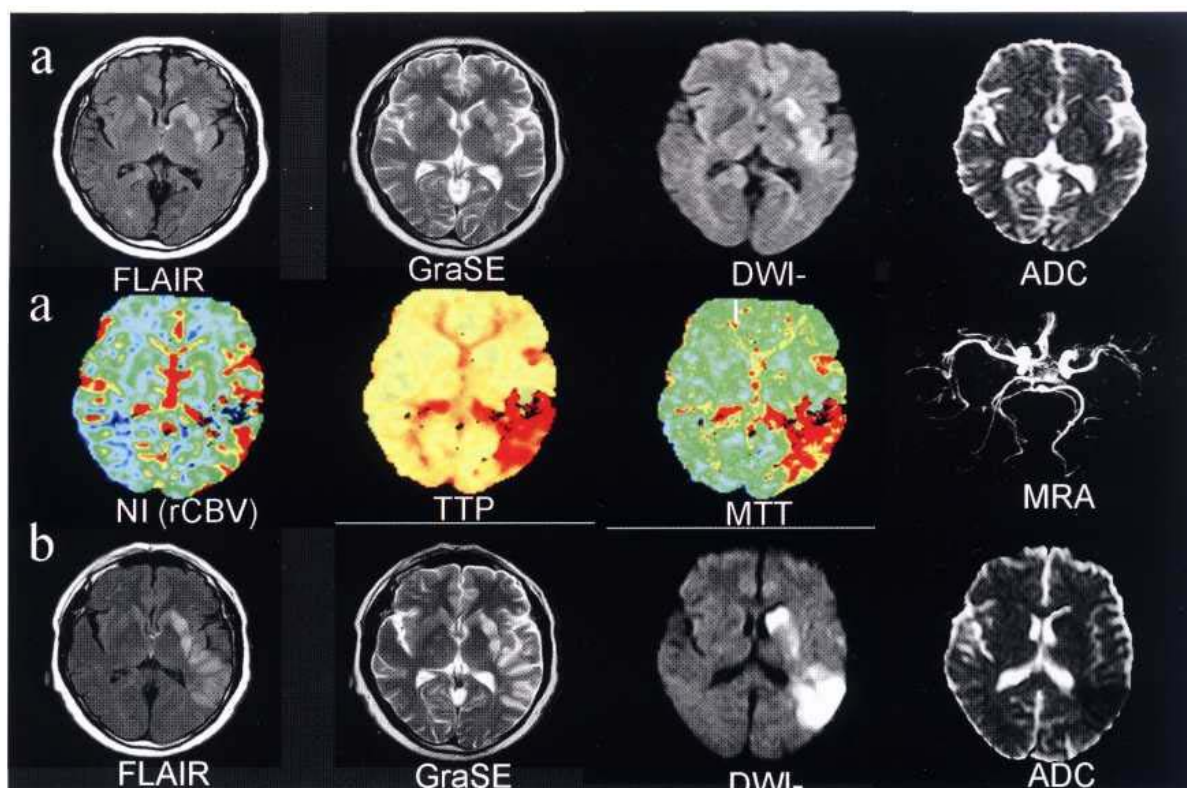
Comprehensive stroke examination performed after (a) 6 h and (b) 24 h from an acute stroke. The protocol includes routine brain sequences in addition to diffusion weighted and dynamic perfusion protocols. The whole examination can be carried out in less than 10 min. The early perfusion and diffusion imaging clearly shows areas of infarct not visible in the standard T_2 and FLAIR images until after 24 hours. (Courtesy of Philips Medical Systems.)
